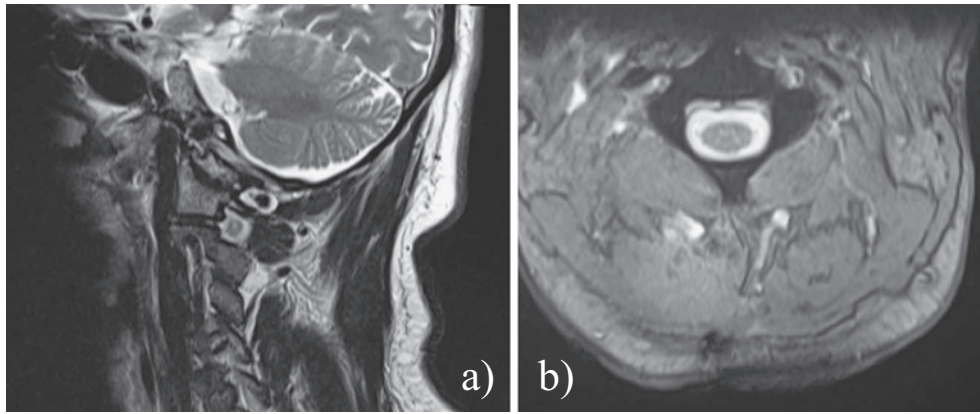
Postoperative cervical MRI images. There is no evidence of the intramuscular lipoma in the deep cervical muscle. Sagittal (a) and axial (b) T2-weighted images.
